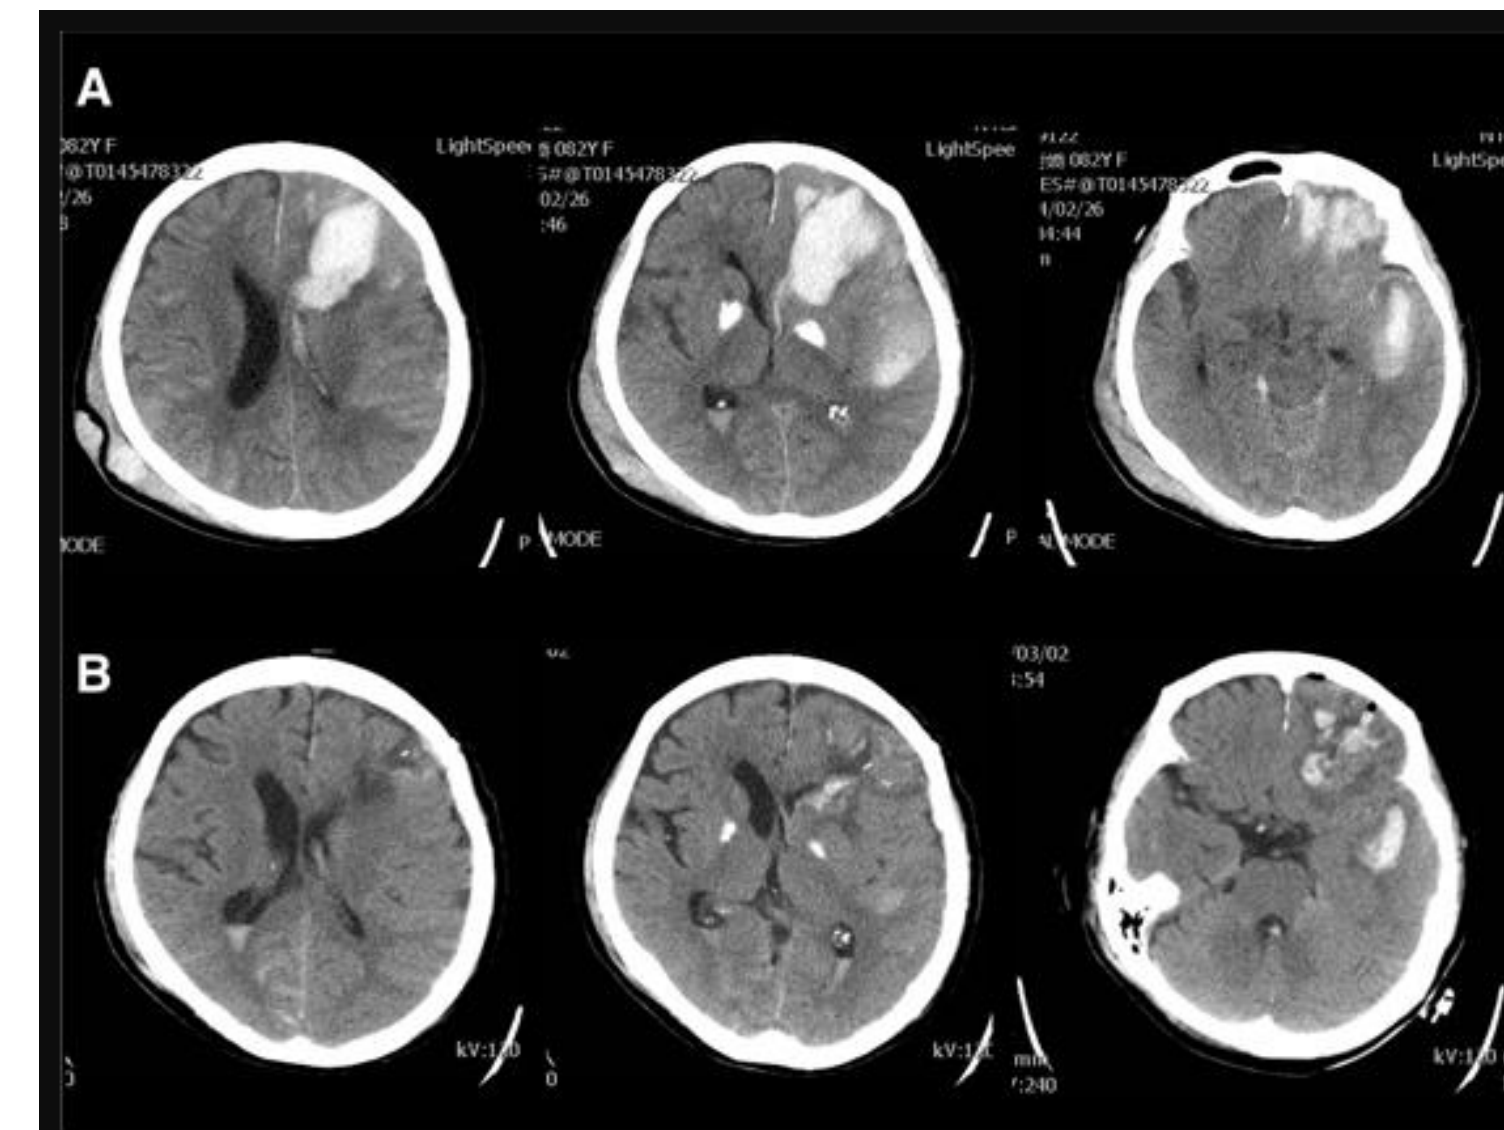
A case of left frontal TICH treated with minimally-invasive surgery with ICP insertion. Pre- (A) and Post- (B) operative CT scan of case 1: isolated TICH.
